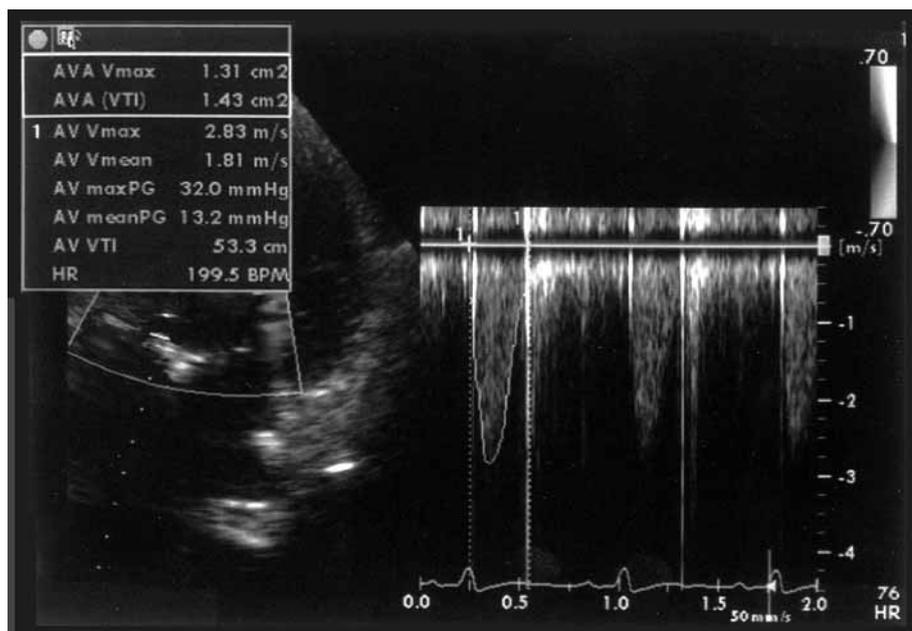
Transthoracic echocardiography two months after the surgery.
